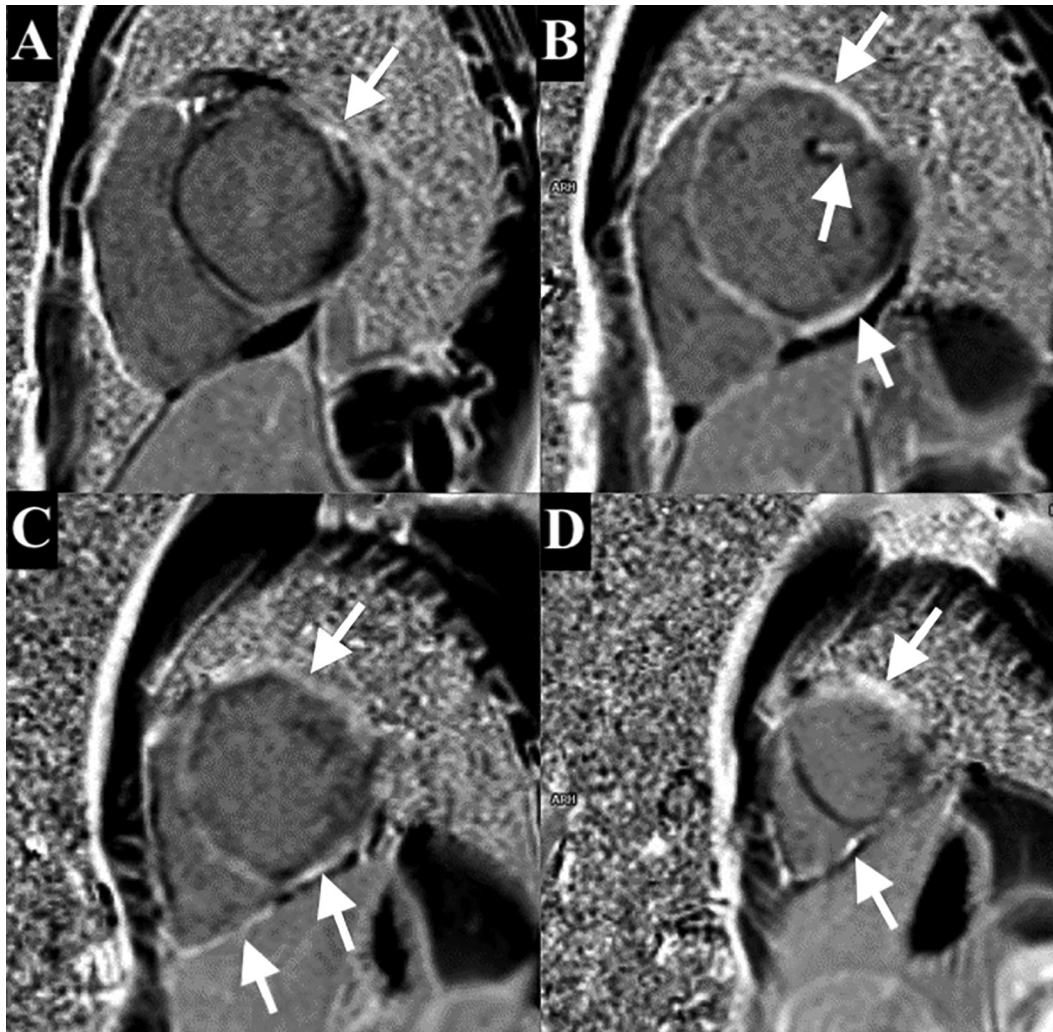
Cardiac MRI of patient Sh. Late gadolinium enhancement in the short-axis view during end-diastole at the basal (A), mid-ventricular (B, C), and apical (D) segments of the left ventricle: multisegmental nonischemic fibrosis with subepicardial, linear intramural, and transmural distribution in the LV myocardium, involving the anterolateral papillary muscle of the LV, trabeculae and papillary muscles of the right ventricle, and localized areas of the posterior RV wall (white arrows). LV = left ventricular, MRI = magnetic resonance imaging.
